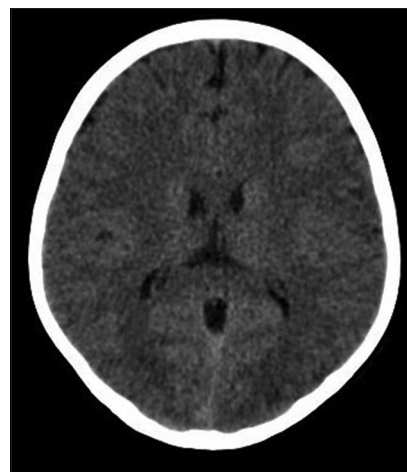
Computed tomography scan of brain showing normal signals of brain parenchyma including occipitoparietal region
